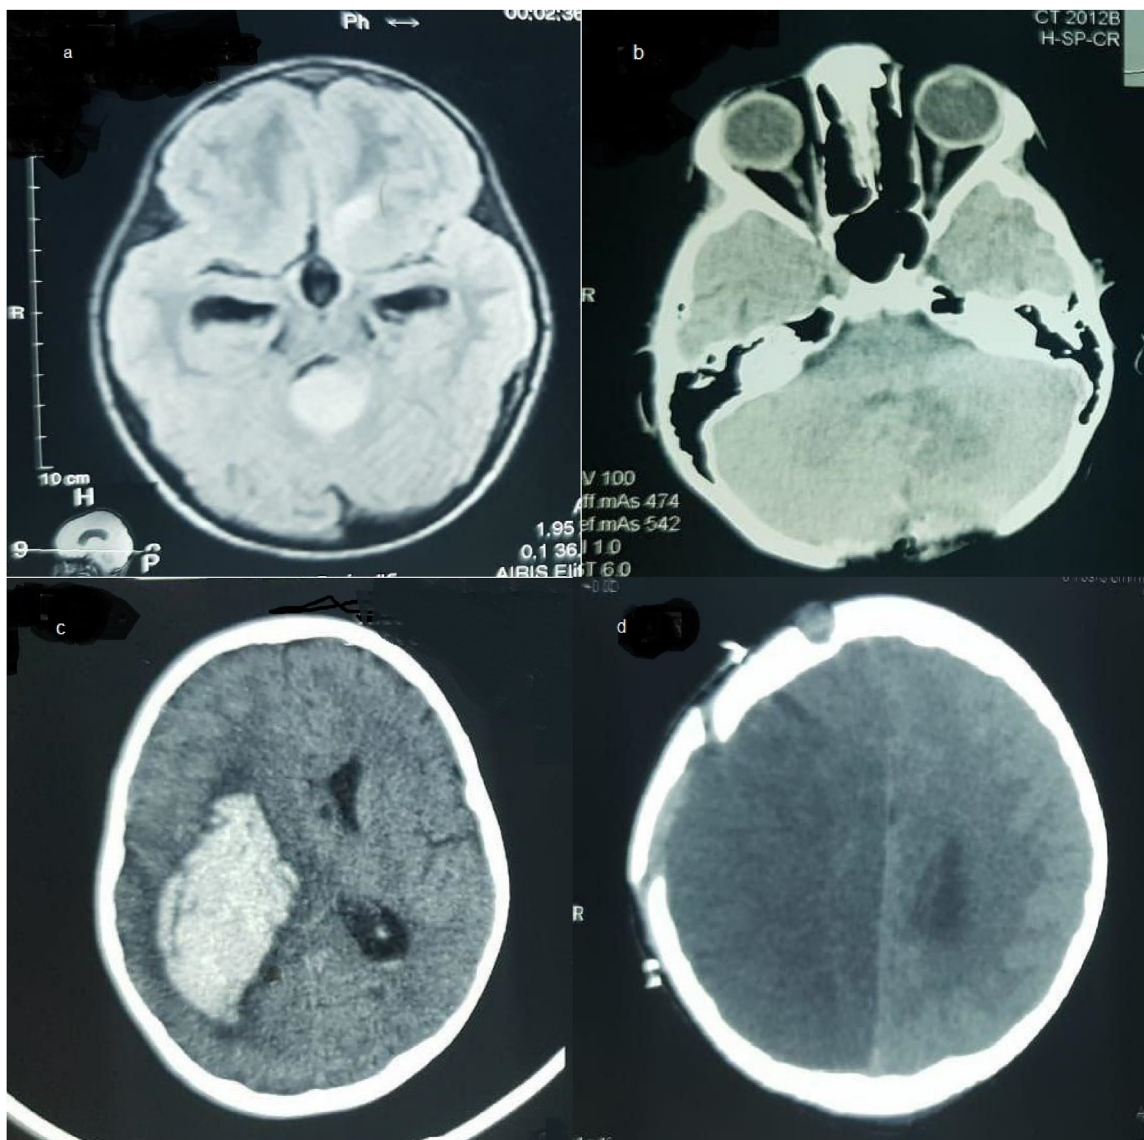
a: Brain MRI shows posterior fossa tumor with hydrocephalus. b: Brain CT scan shows a totally removed tumor with craniectomy after 10 days of surgery. c: Brain CT scan reveals right temporo-parieto-occipital ICH on post-operative day 35. d: An extensive right hemispheric ischemia was discovered on day 9 after evacuation of ischemia.
